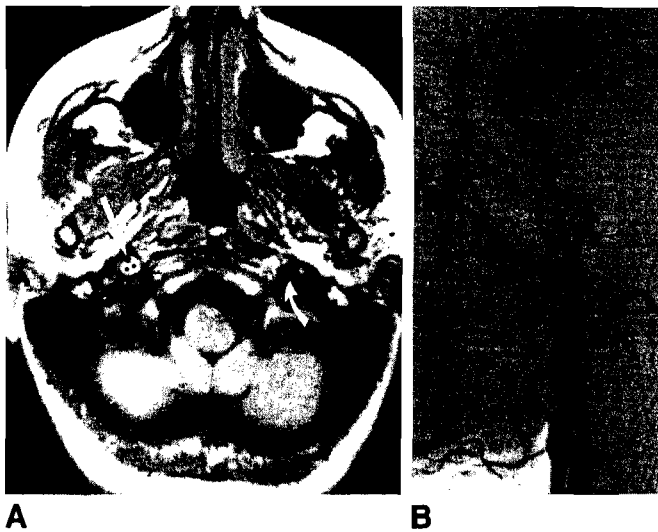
A, Axial T1-weighted MR scan in a patient with postganglionic Horner's syndrome. Compared to the normal flow void of the internal carotid artery on the left (*curved white arrow*). The right carotid artery flow void is very diminutive (*white straight arrow*). There is high signal intensity surrounding the vessel, compatible with hemorrhage (*dots*) indicating internal carotid artery dissection (600/20/2).
